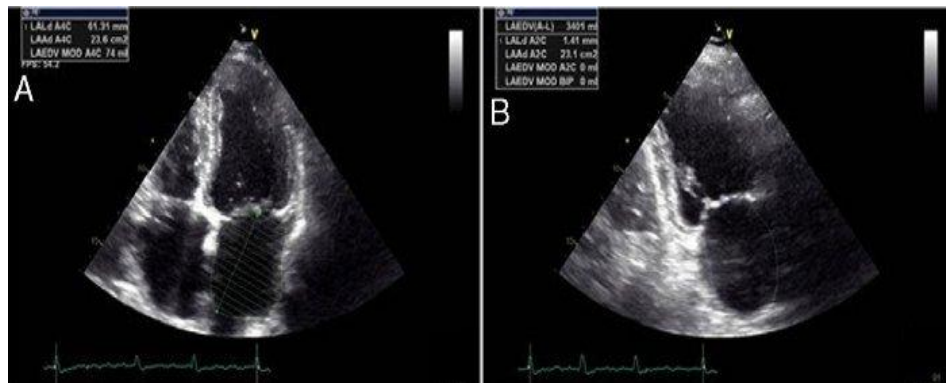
Assessment of left atrial volume using Simpson's method in A4C and Apical 2-chamber (A2C) views
